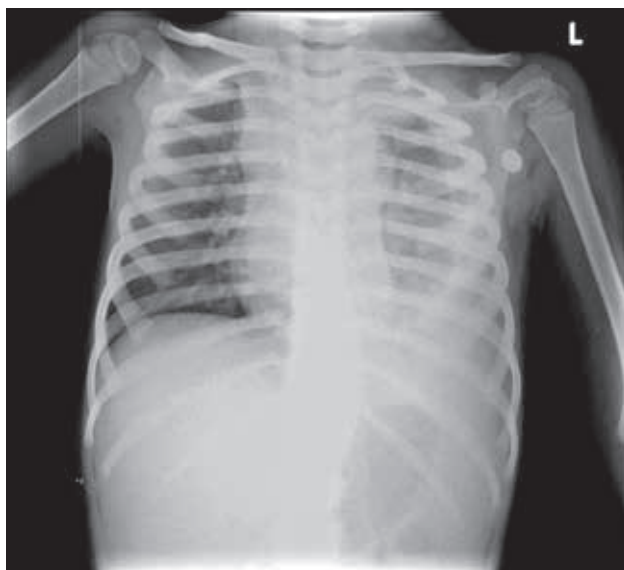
Chest x-ray showing paracardiac haziness, hilar widening and left sided pleural effusion
